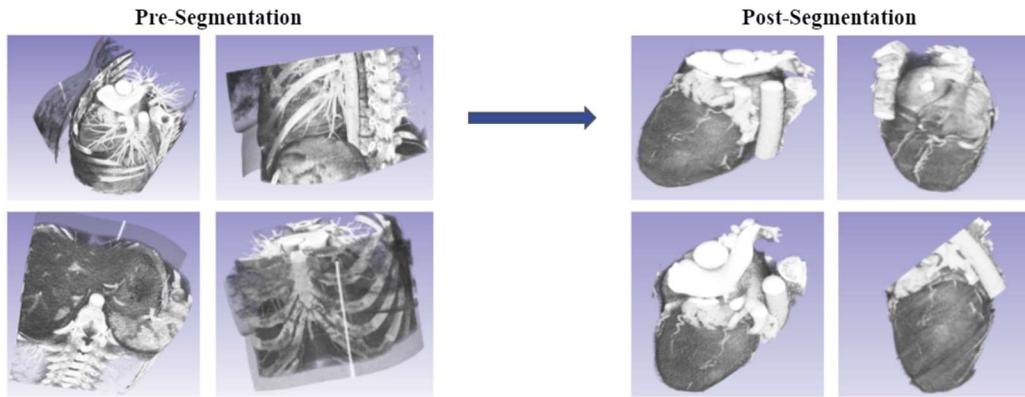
Results After Segmenting a Single Set of Chest CT Scan Data
